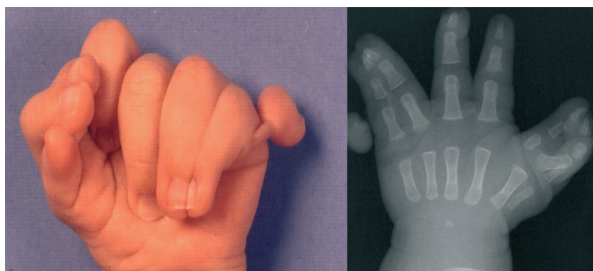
Preoperative picture and x-ray of right hand of case 4
